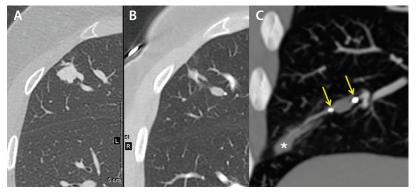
CT pulmonary angiogram. Pretreatment CTA demonstrating the PAVM and feeding vessel (A). Follow-up CTA at 3 months demonstrating involution of the PAVM and no further enhancement (B). Coronal multiplanar reformat image showing the stability of the MVP™ plug within the thrombosed feeding artery (yellow arrows show the radiopaque markers of the MVP-5Q™ plug) (C). Asterisk (*) signifies a small area of distal infarct with scarring.
